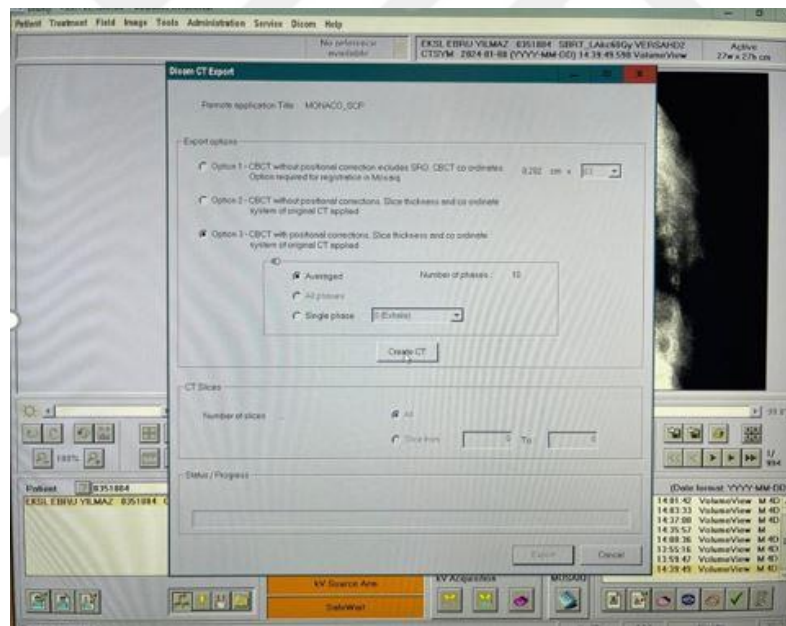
Transmission of 4DCBCT images to the Monaco treatment planning system using back projection.
